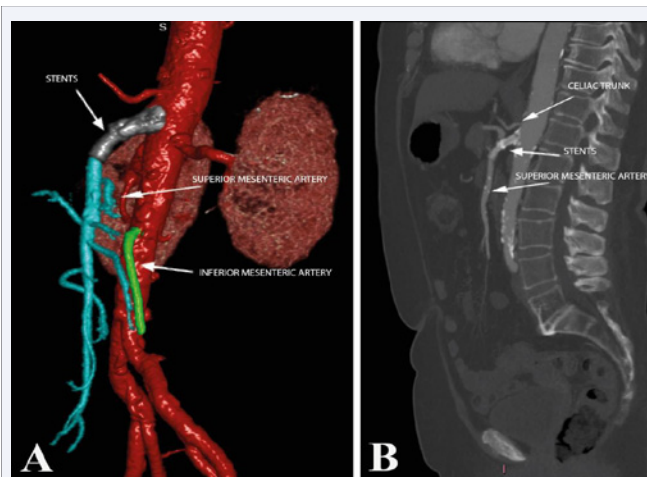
A CT angiography showing the resolution of superior mesenteric artery occlusion six months after stenting.
